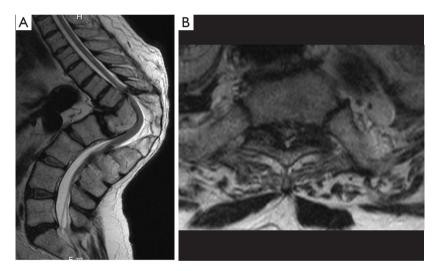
MRI. (A) T2 sagittal MRI shows hypertrophied ligamentum flavum and anterior disc osteophyte complex causing compression of spinal cord. No cord signal change was noted at the apex of the deformity; (B) T2 weighted MRI axial section shows significant cord compression by disc osteophyte complex and hypertrophied ligamentum flavum. MRI, magnetic resonance imaging
